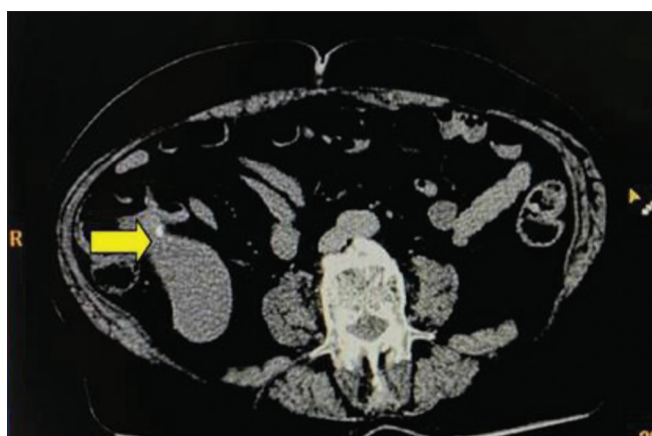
Mucocele of Appendix: Axial CT image showing well-circumscribed, hypodense, dilated, tubular structure in the right iliac fossa, contiguous with the base of the caecum. A calcific focus is seen in its wall. No periappendiceal fluid or fat stranding is evident
